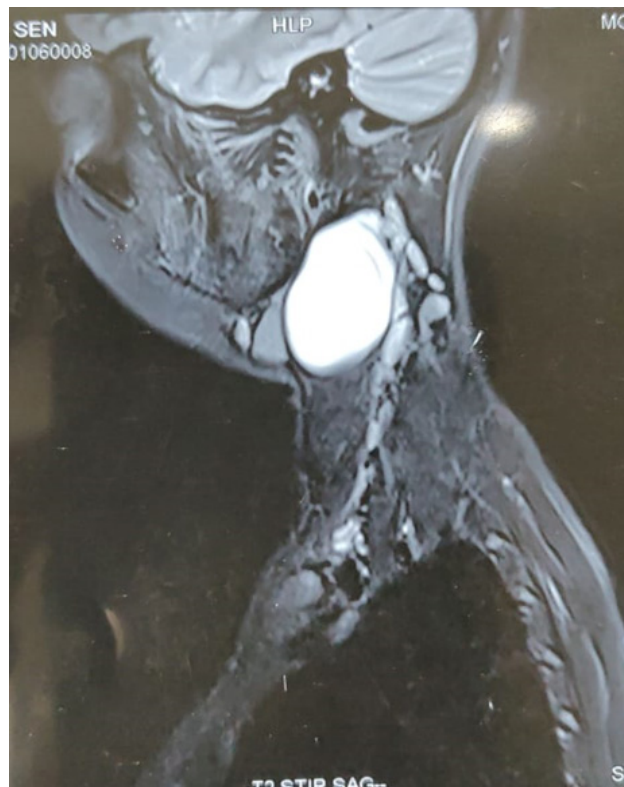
MRI with contrast was carried out to find the extent of the cyst and its relation to the internal jugular vein and carotid artery.
